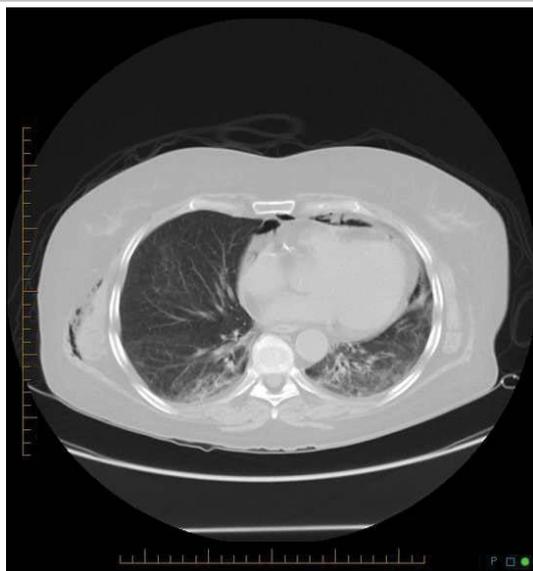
Non-contrast computed tomography scan of chest. Coronal view demonstrates linear interstitial opacities more prominent in the left lung. Spontaneous pneumomediastinum seen between the anterior chest wall and cardia. Subcutaneous emphysema visualized lateral to the right thorax.
